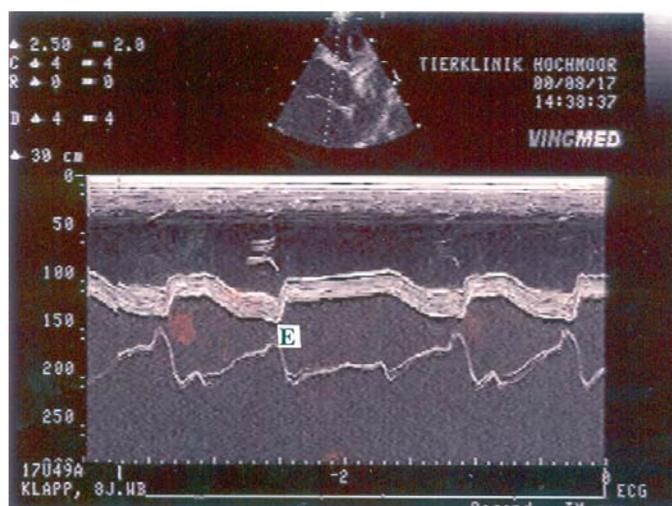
M-mode echocardiogram obtained at the level of the ventricles, showing the mitral valve with the lack of an A-peak, a irregular rhythm with diastolic undulation.
